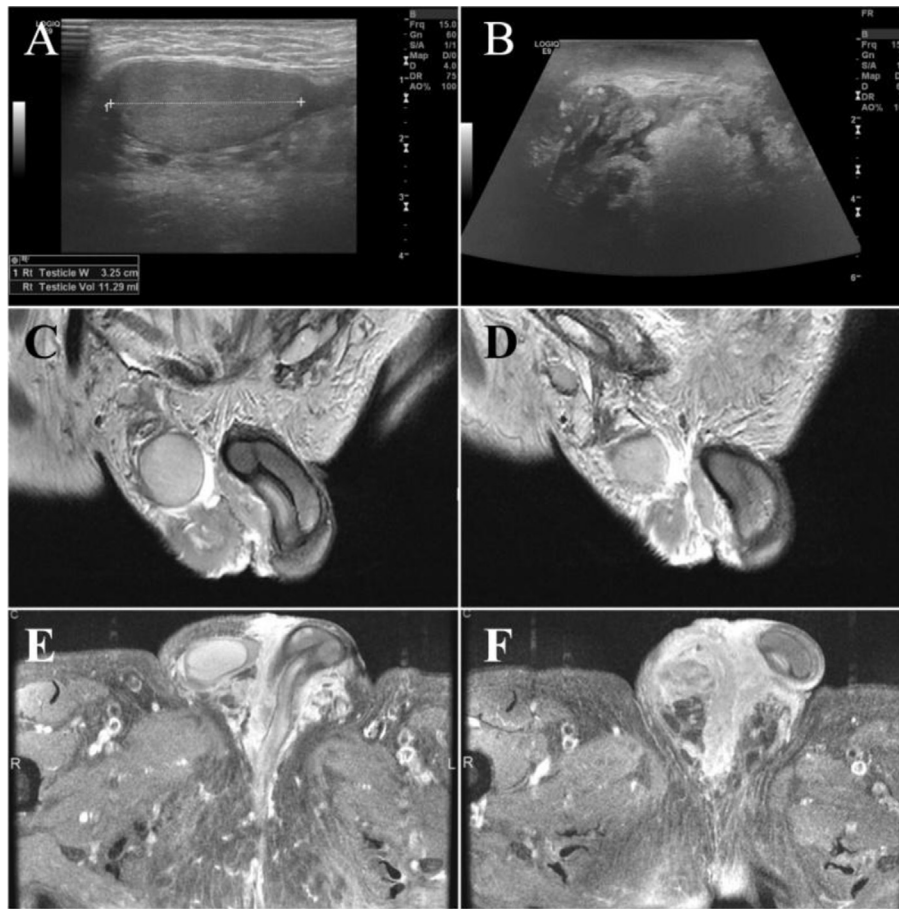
Scrotal ultrasound (A, B). Inguino-scrotal MRI (C, D, E, F).
